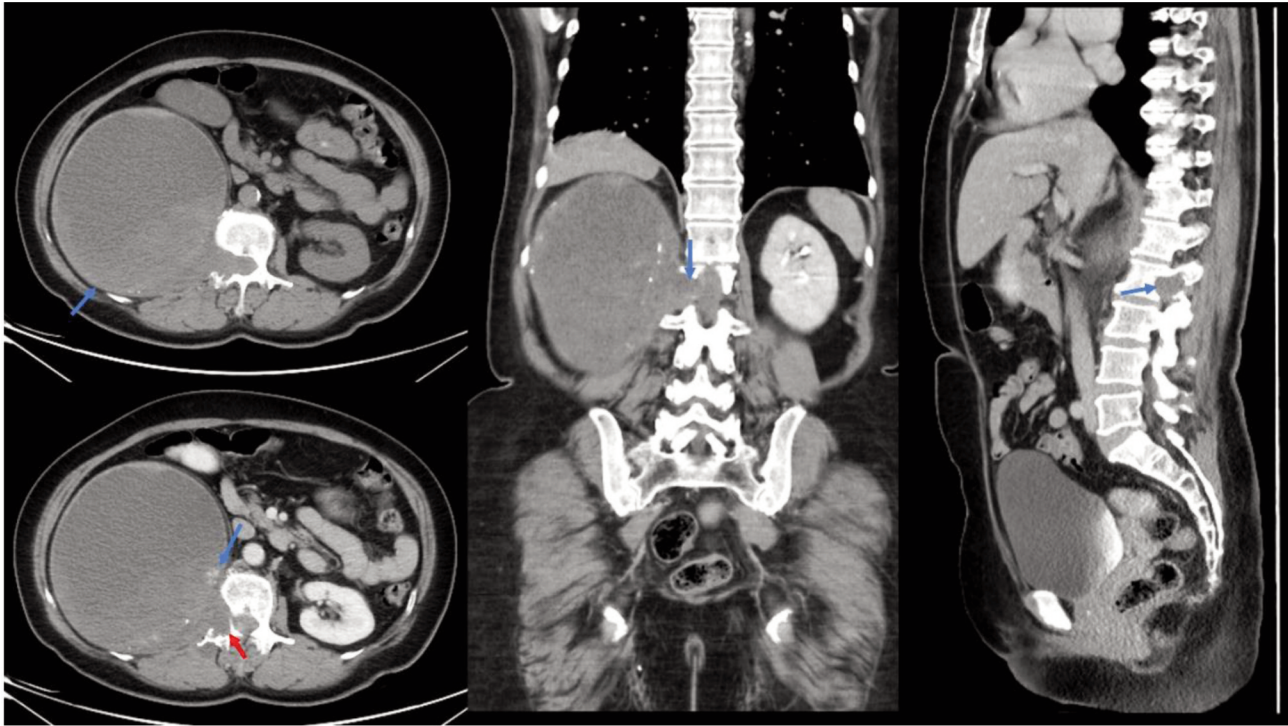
Abdominal CT revealed a suspected retroperitoneal cystic tumor. A 15.4×15.3×15.8 cm tumor arisen from the right neuroforamen of L2 showed cystic, solid, blood product and calcified content (blue arrows). Destruction of perifocal vertebral bone and pedicle are also noted (red arrow). CT: Computed tomography.
